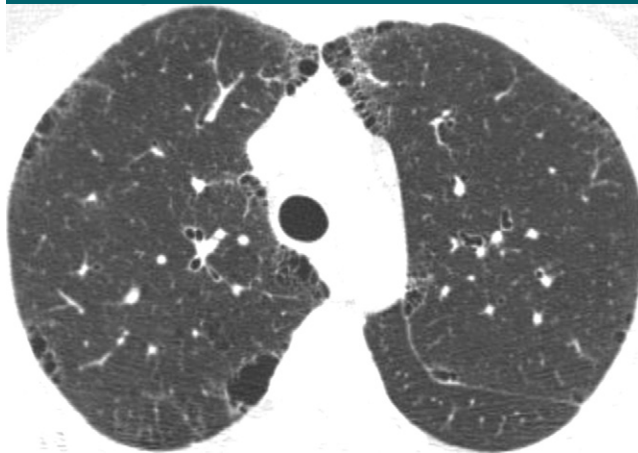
Substantial PSE. CT scan in patient with GOLD stage I COPD shows numerous well-demarcated areas of subpleural emphysema along chest wall and mediastinal pleural margins.
